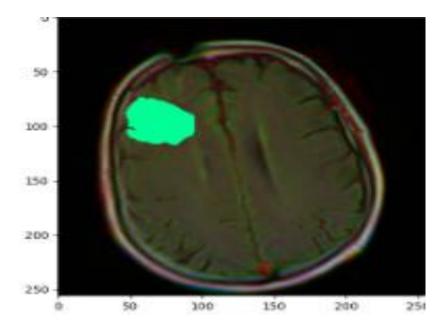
Brain MRI with predicted mask
